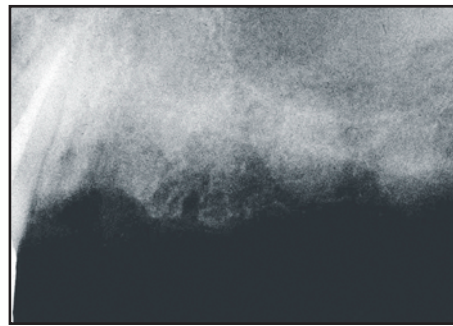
Preoperative radiograph 3 months after the loss of tooth #12(24) and the cantilevered prosthesis.
